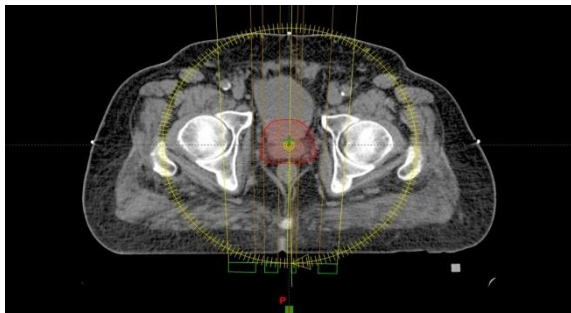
presents an axial computed tomography slice showing the VMAT plan with PTV contoured, the yellow circle indicates the gantry rotation.
